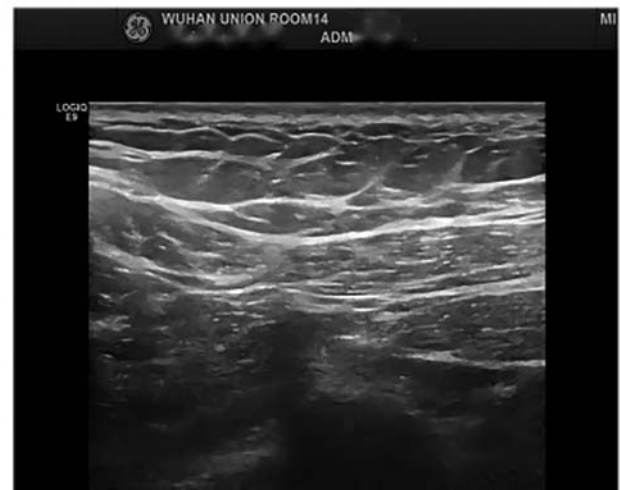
Ultrasound images of the left breast. Complete response of the left breast after six cycles of neoadjuvant therapy.
